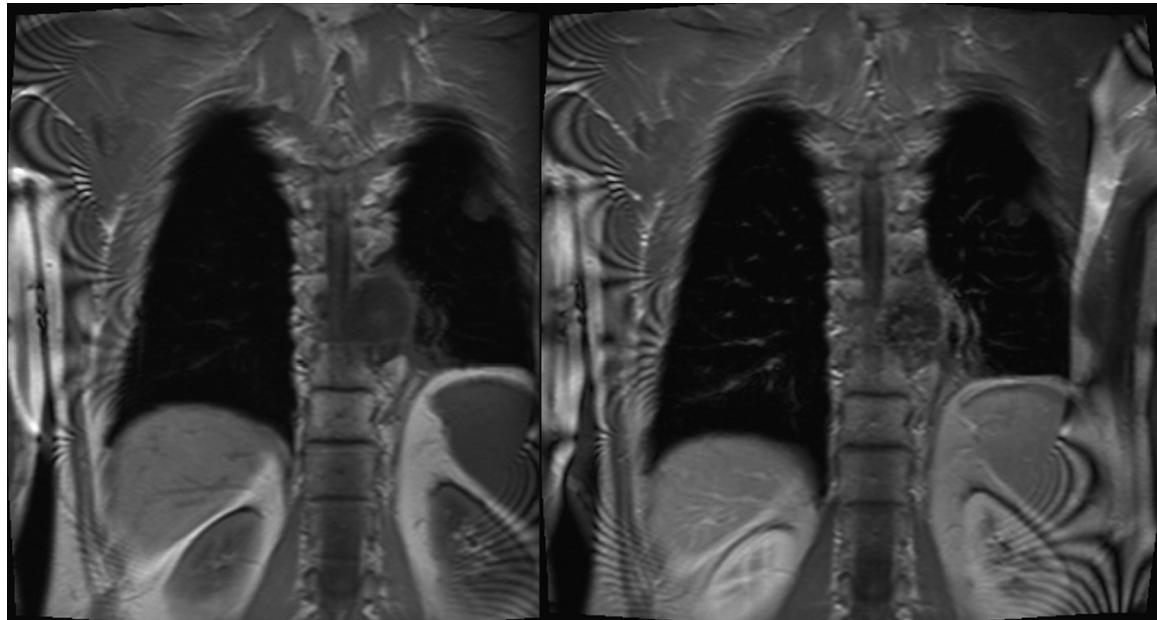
Coronal precontrast (Left) and postcontrast (Right) T1-weighted MR images show the heterogenous contrast-enhanced mass lesion.
